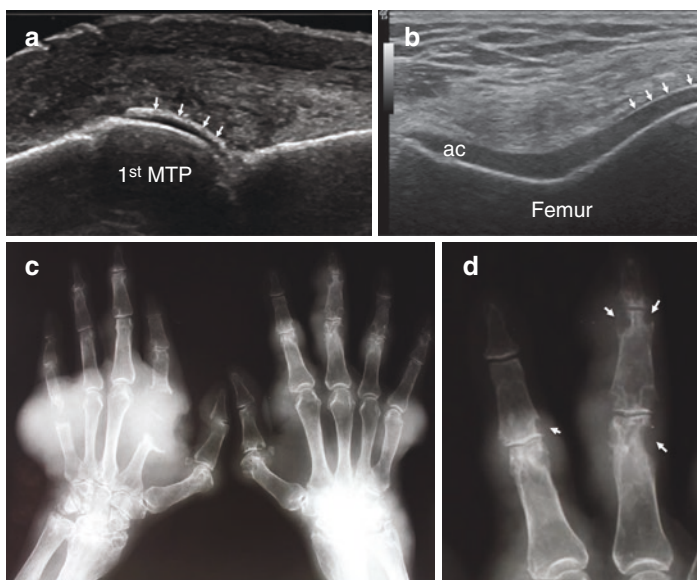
Imaging modalities in gout. Point-of care ultrasound showing a “double-contour sign” (arrows) on the surface of articular cartilage (ac) on a longitudinal view of the 1st MTP (a) and knee (b) of the hyaline cartilage. (c) Conventional radiography of the hands showing erosive gouty arthropathy in a patient with tophaceous gout. (d) Higher magnification of the right second and third digit highlighting cortical break with sclerotic margin and overhanging edge (arrows) seen on conventional radiography. 1st MTP metatarsophalangeal joint, ac hyaline cartilage
